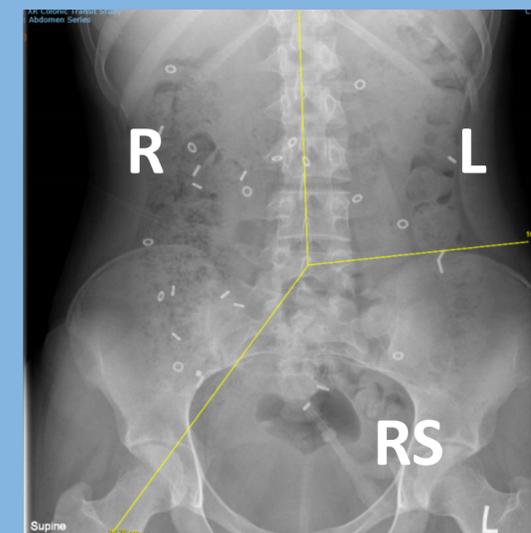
Colonic segments in abdominal X-ray (R- right colon; L- left colon; RS- rectosigmoid colon). Spinal processes and imaginary lines from fifth lumbar vertebra to right pelvic outlet and left iliac crest, serving as landmarks defined projection zones of right, left and rectosigmoid colon. [2,3]
